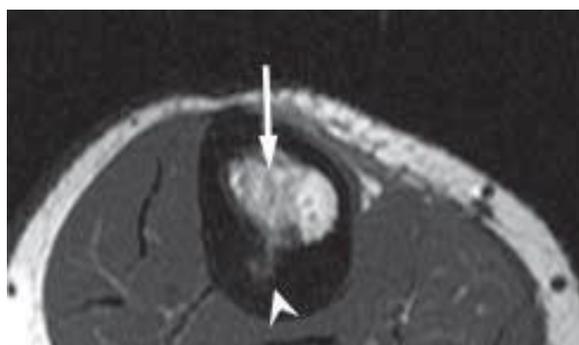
MRI showing nidus surrounded by zone of ablation
